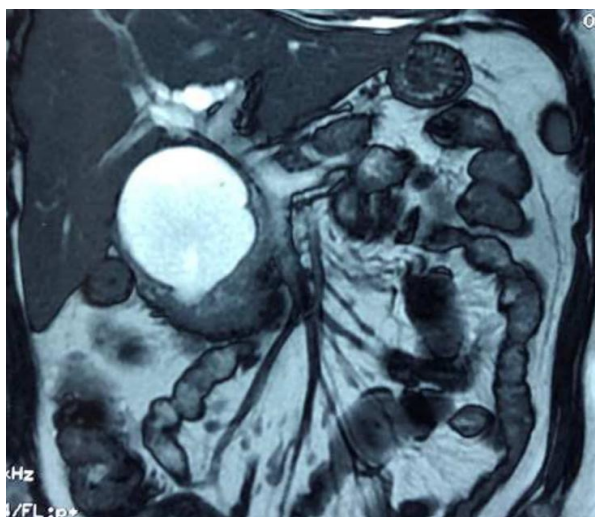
Coronal section in T2-weighted sequence of abdominal MRI showing a fusiform and homogeneous cystic dilation of the main bile duct, with slight dilation upstream of the intrahepatic bile ducts.
